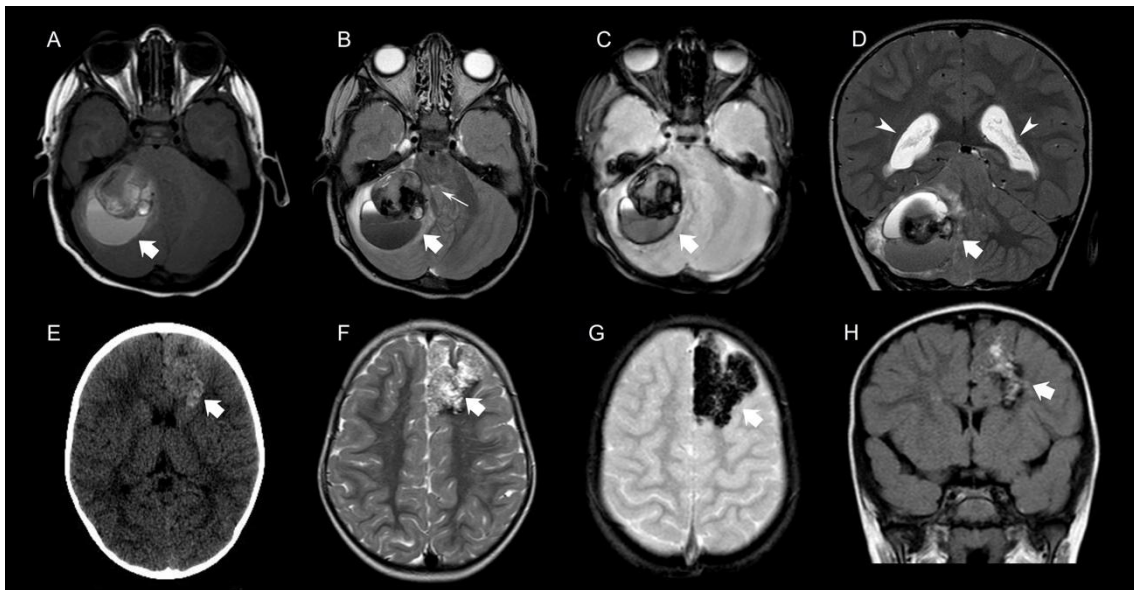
Brain MR in a child presenting with ataxia including axial T1WI (A), T2WI (B) and magnitude SWI (C) images as well as coronal T2WI (D) image reveals a very large, multilobular, expansile lesion in the right cerebellar hemisphere, with a hemosiderin rim and multiple areas of hemorrhage of different ages including inner blood-levels, compatible with a multicystic type of giant cerebral cavernous malformation (CCM) (*thick white arrows*). Note the small area of peripheral edema as well as the associated mass effect, including severe compression of the IV ventricle (*very thin white arrow*) and mild dilatation of the occipital horns of the lateral ventricles associated with, in keeping with supratentorial obstructive hydrocephalus (*white arrowheads*). Axial unenhanced head CT image (A) and brain MR including axial T2WI (B) and magnitude SWI (C) and coronal FLAIR (D) images obtained in another child demonstrate a very large intra-axial lesion in the left frontal lobe, partially calcified, and with associated blooming effect compatible with reticulated type of giant CCM (*thick white arrows*). There is no associated vasogenic edema nor significant mass effect.
